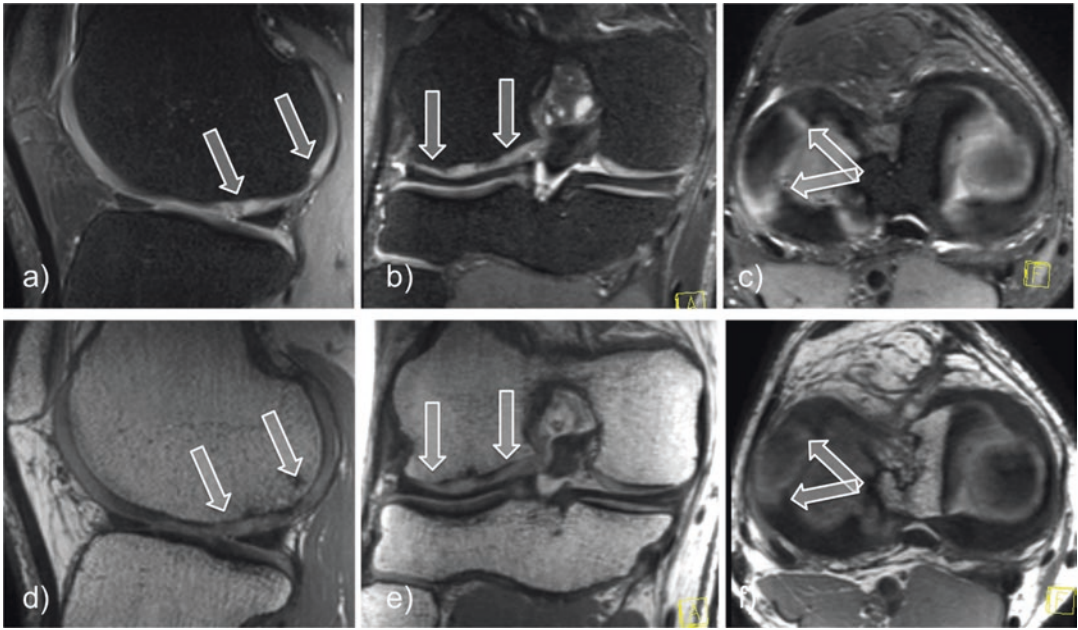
Morphological fat-saturated (a–c) and nonfat-saturated (e–f) PD-TSE MRI of a knee joint 36 months after microfracture therapy of the lateral femoral condyle (arrows) in three planes (a, d: sagittal, b, e: coronal, c, f: axial). Especially for the evaluation of the subchondral bone plate, the need for different contrast setting is observed. The images depict a clearly visible
